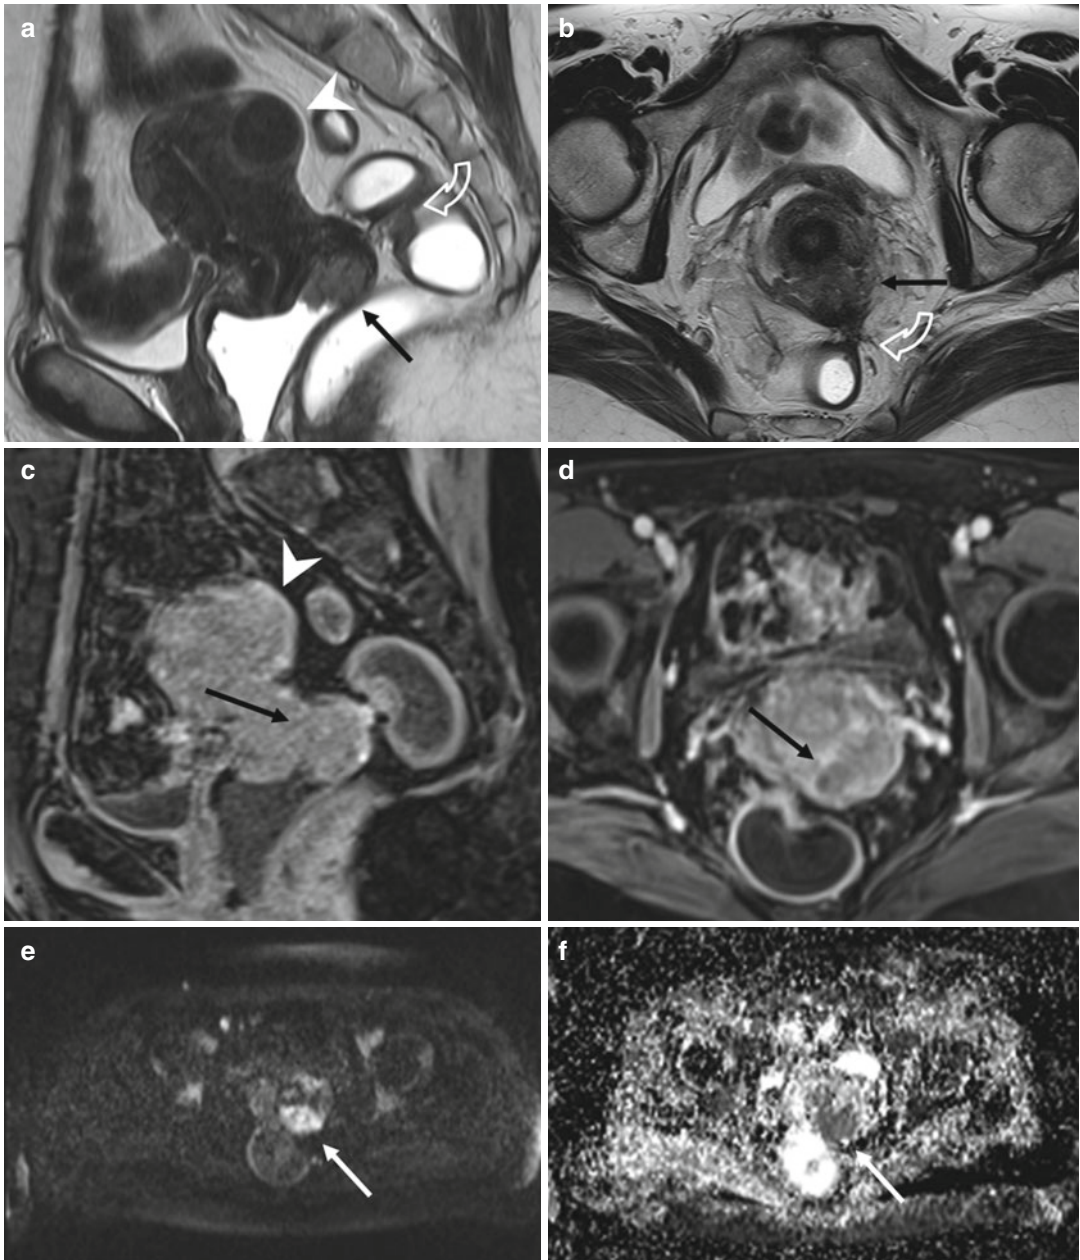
Malignant transformation in endometriosis. Sagittal (a: TR 3857, TE 100) and axial (b: TR 3652, TE 100) T2-weighted MR images show a cervical lesion in the posterior fornix (*arrows*) in a patient with endometriosis of the posterior compartment (*curved arrows*). It exhibits enhancement on the T1-weighted image after
